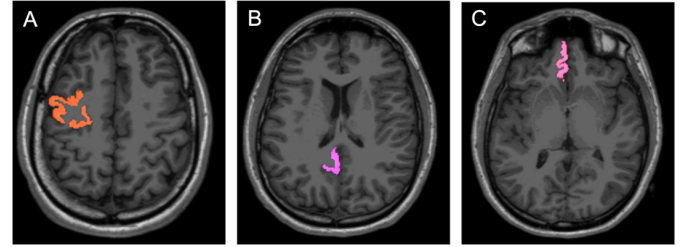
Region of interest displayed in the T1-weighted MRI. (A) Caudal Middle Frontal (cMFG), (B) Isthmus Cingulate Cortex (ICC), and (C) Medial Orbitofrontal (MOF)
